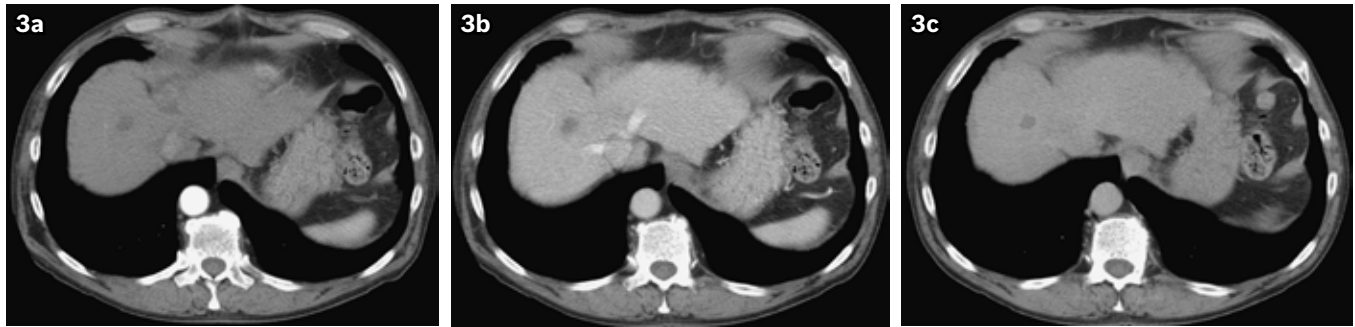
(a) Hepatic arterial; (b) portal venous; and (c) delayed phase CT images ten months after the initial presentation show continued tumour regression with reduction in size of the known hepatocellular carcinoma and a small residual cystic area, which is likely necrosis. No residual areas of enhancement are seen with the mass.
